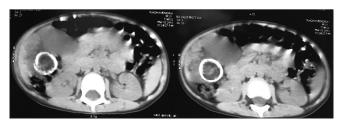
Computed tomography showing intra-abdominal calcified lesion
